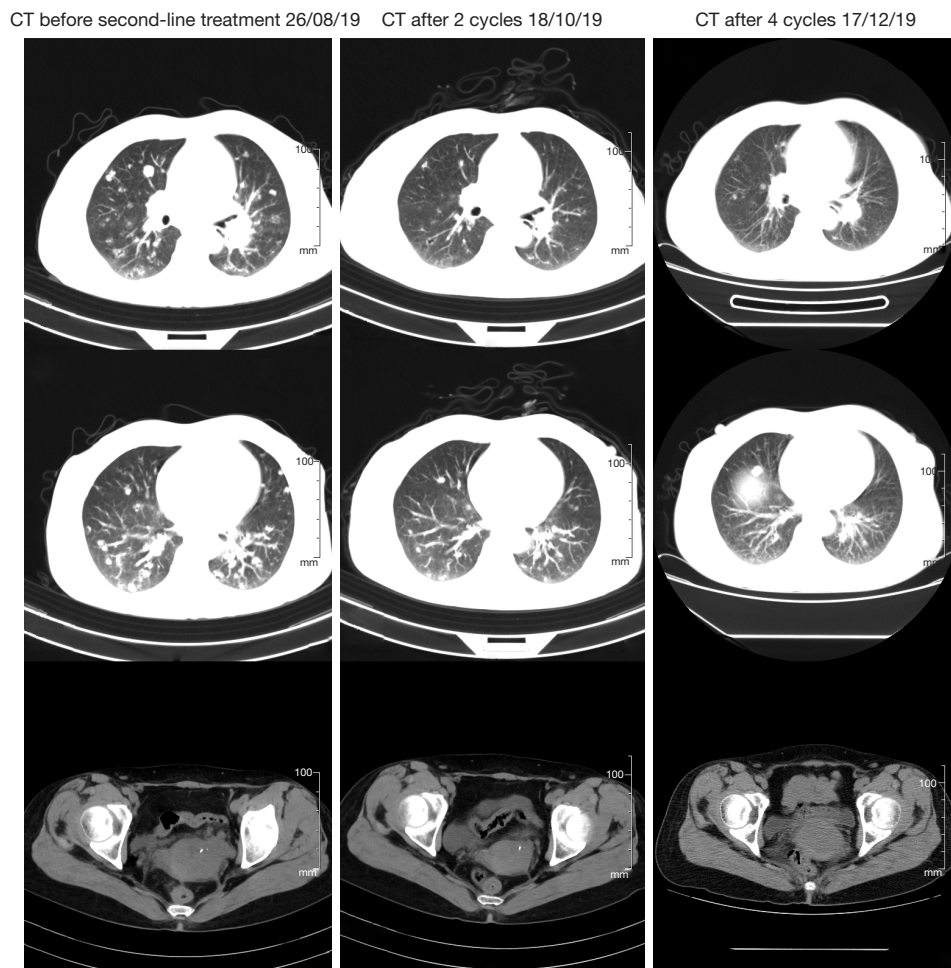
Comparison of primary cervical and pulmonary metastatic foci during the second-line treatment of the patient. CT, computed tomography.
